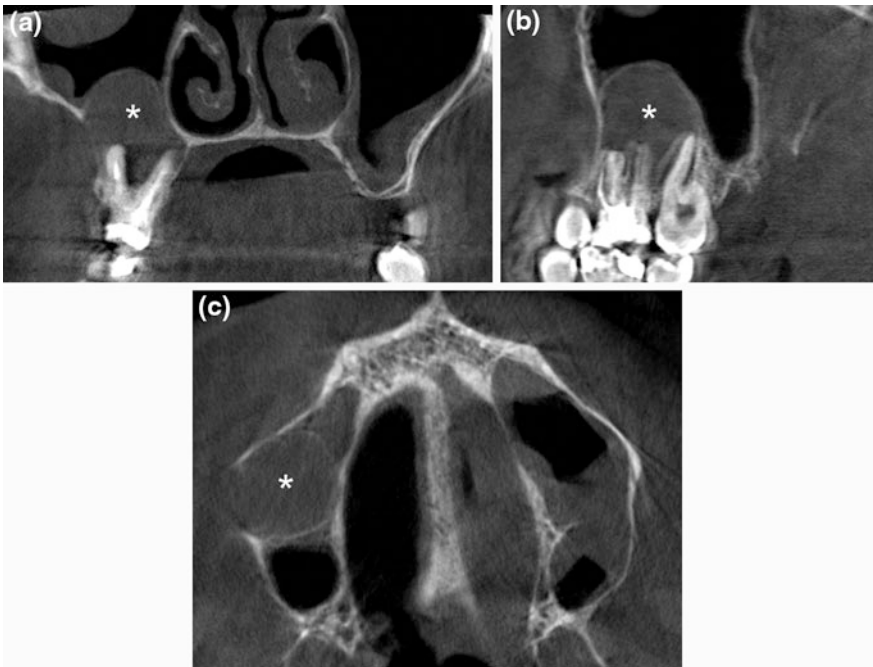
CBCT coronal (a), sagittal (b) and axial (c) sections showing an oval radiopaque with well-defined peripheral borders (*). The pathology involves the apical region of tooth 16 and 17, and protrudes into the adjacent right maxillary sinus. Note the moderate bilateral maxillary sinus mucosal thickening without blockage of both osteomeatal complexes
